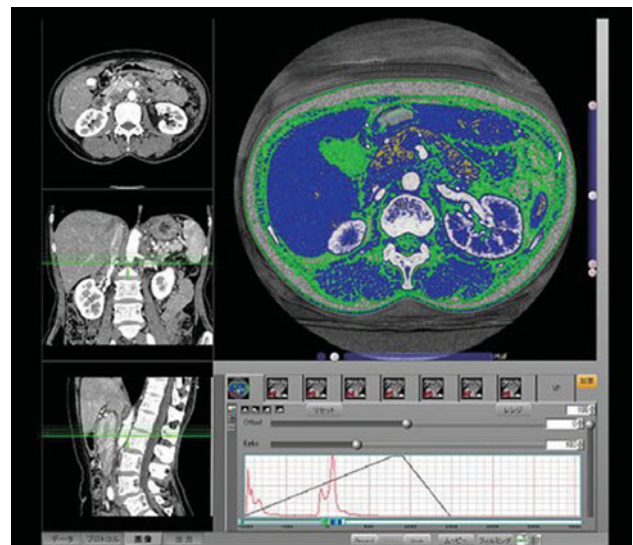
Full scale volume-rendering CT
